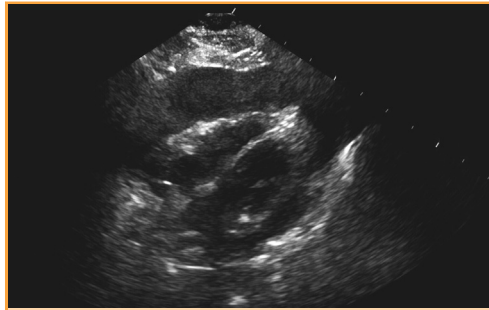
Transthoracic echocardiographic subcostal 4-chamber view showing a large circumferential pericardial effusion. Image courtesy of Dr S. Allen Luis, Division of Cardiovascular Diseases, Mayo Clinic.
